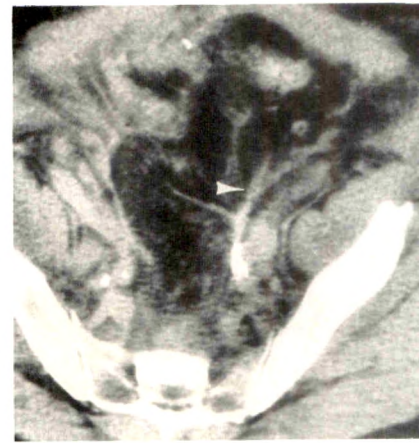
Underestimation of extent of disease by CT in a 59-year-old man with mesenteric recurrence. CT scan shows soft-tissue strands in mesentery (arrowhead). Surgery later revealed extensive tumor infiltration. Interpretation was made more difficult because bowel loops did not opacify with contrast material.
